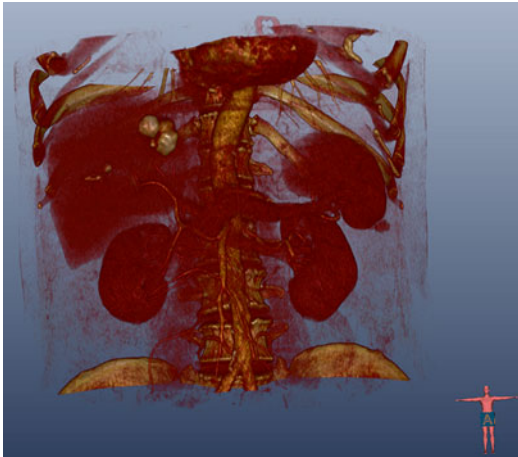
The volume rendering imaging of CT data. These 3D images have more rich internal details than the surface rendering 3D images, but their interactive performance and efficiency of the algorithm are poor
